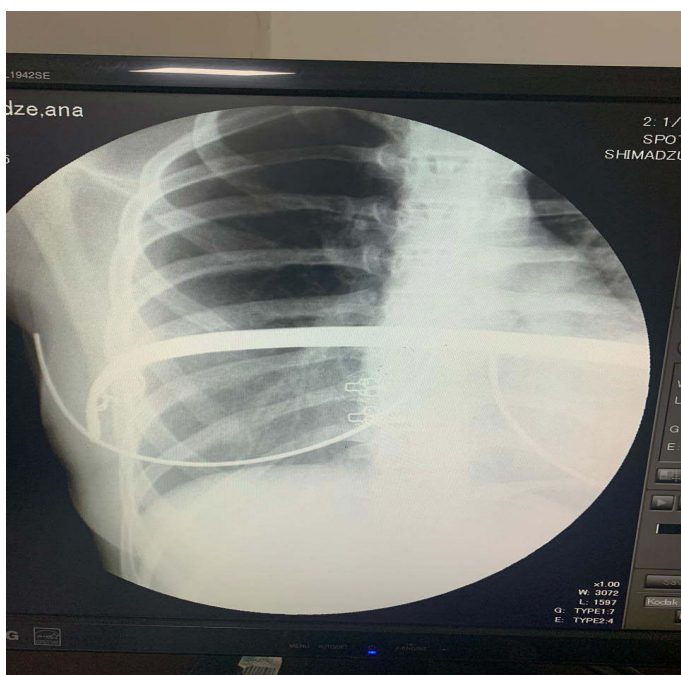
Case N2: Patient A.A. Complication: Rotated implant. X-ray.
